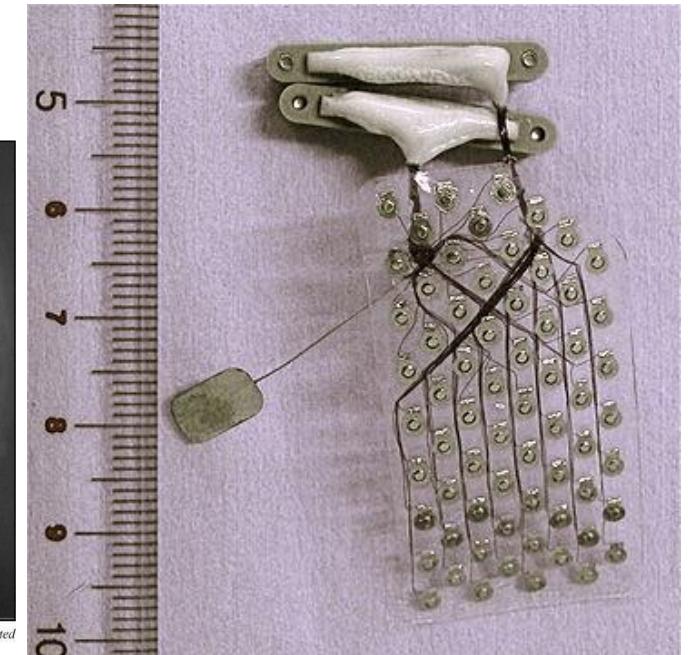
Skull X-ray showing the typical position of the bilaterally implanted subdural grids.
